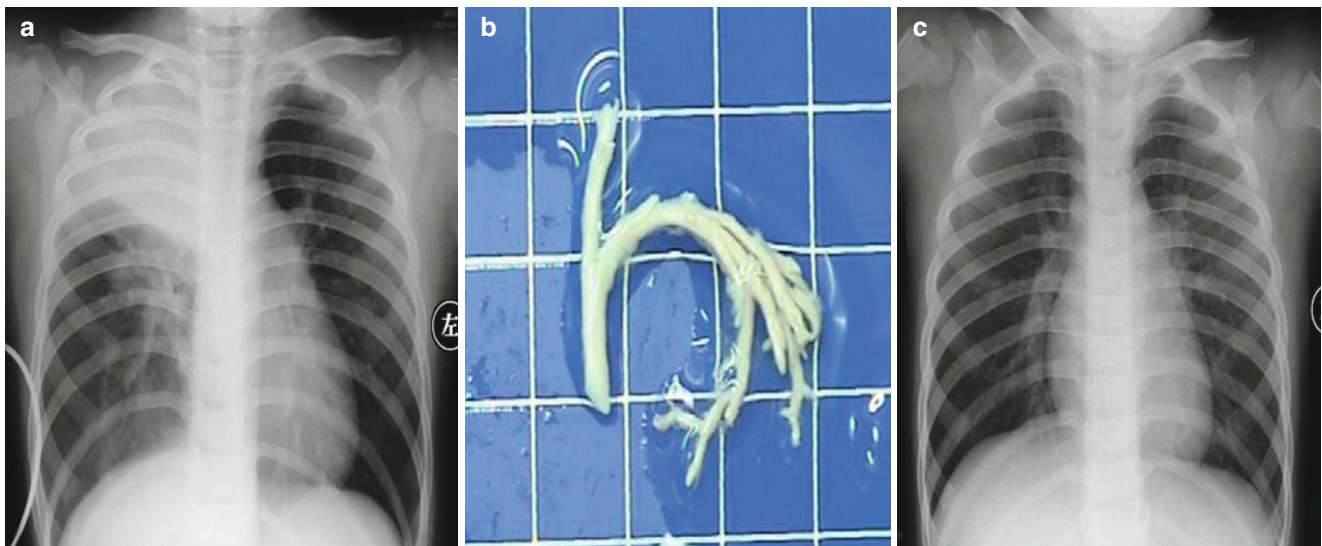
(a–c) A boy aged 3 years with influenza A (H1N1) complicated by pneumonia. (a) At d 6 since onset, chest X-ray showed inverted triangle-shaped dense opacities at the right upper lung field, indicating lung consolidation and partial atelectasis. (b) At d 7 since onset, fiberoptic bronchoscopy showed obstructed bronchi at the right upper lung lobe.
